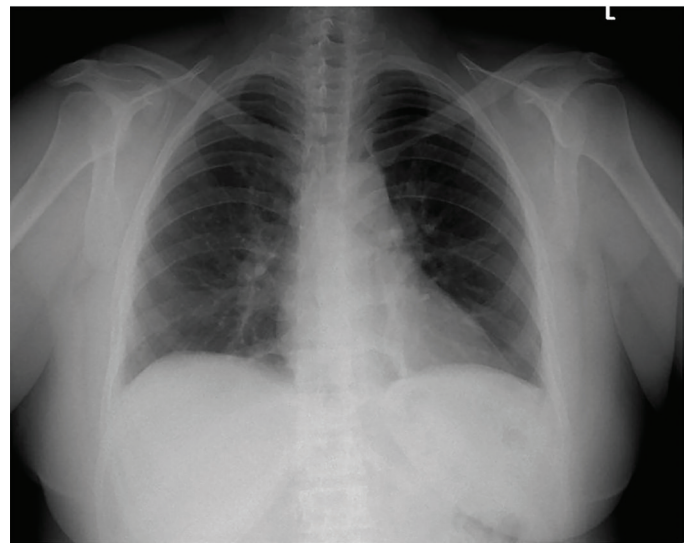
Postoperative posteroanterior chest X-ray of the patient
